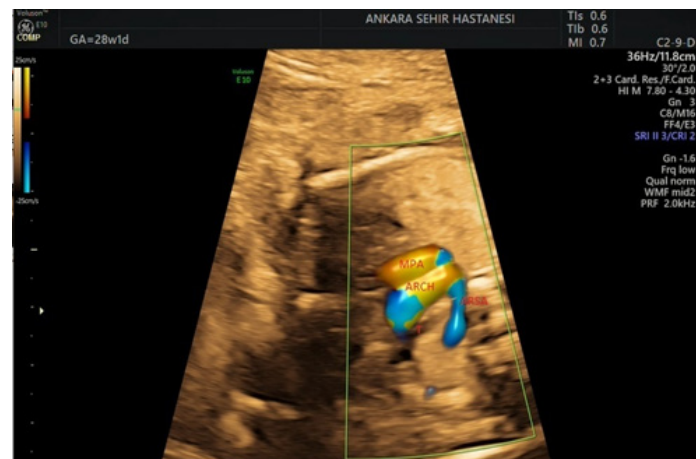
Ultrasound View of Fetal ARSA
